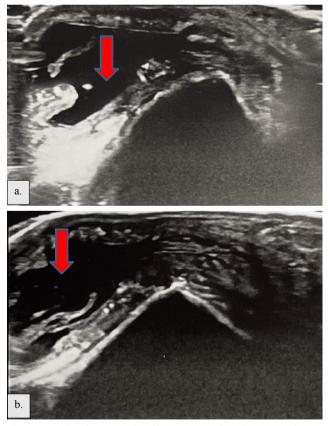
A-B*) Ultrasound: effusion into the olecranon bursa (arrows).
